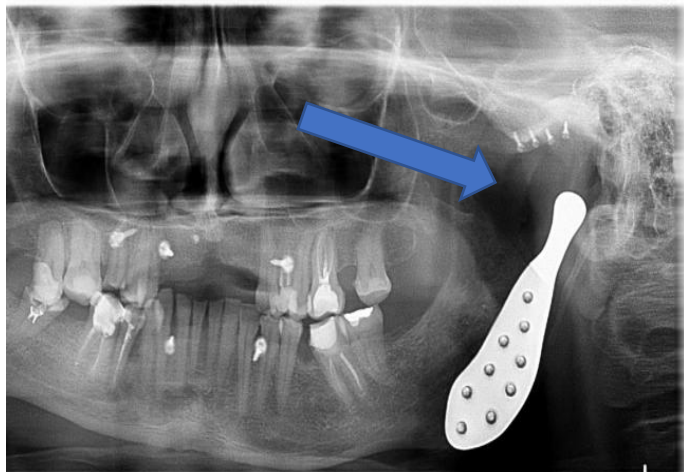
Orthopantomogram of the individual implant's stable position during follow-up 3 months after the surgery presenting stable implant positioning. The prosthetic head was displaced posteriorly and slightly laterally relative to the artificial fossa (indicated by blue arrow) (RadiAnt DICOM Viewer 2025.2).
